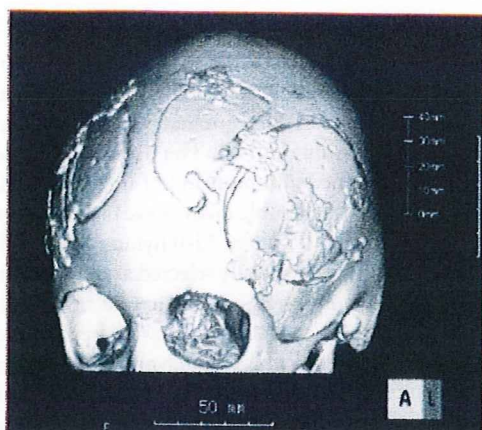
Postoperative 3-dimensional computed tomography scans of the skull of an 8-year-old girl who underwent superficial temporal artery to middle cerebral artery anastomosis and encephalo-duro-myo-arterio-pericranio-synangiosis on both sides. Note the wide cranial windows for surgical revascularization.
